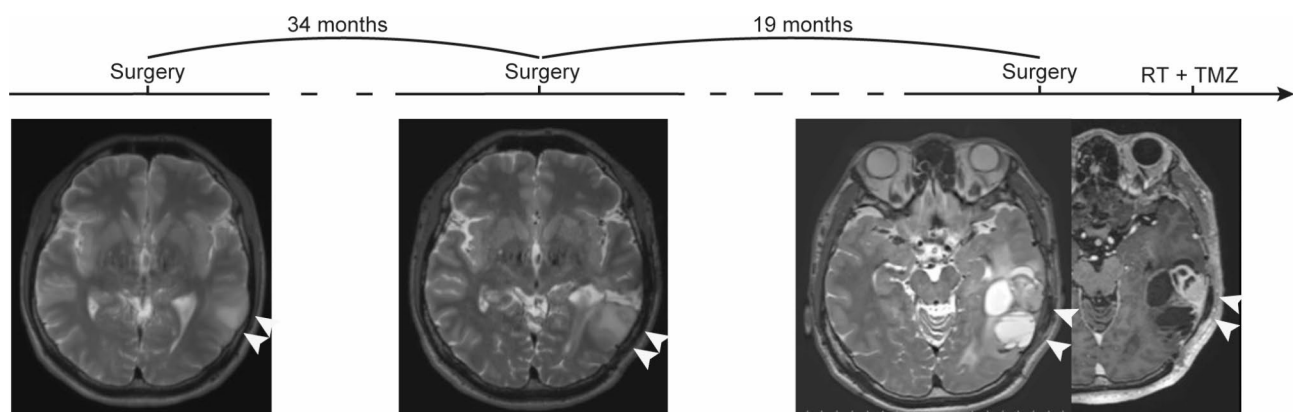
Summary of clinical course of the patient. MRI sequences of T2-weighted image (T2WI) and gadolinium-enhanced T1-weighted image (T1WI) are shown. White arrows indicate abnormal lesions. RT, radiation therapy; TMZ, temozolomide
